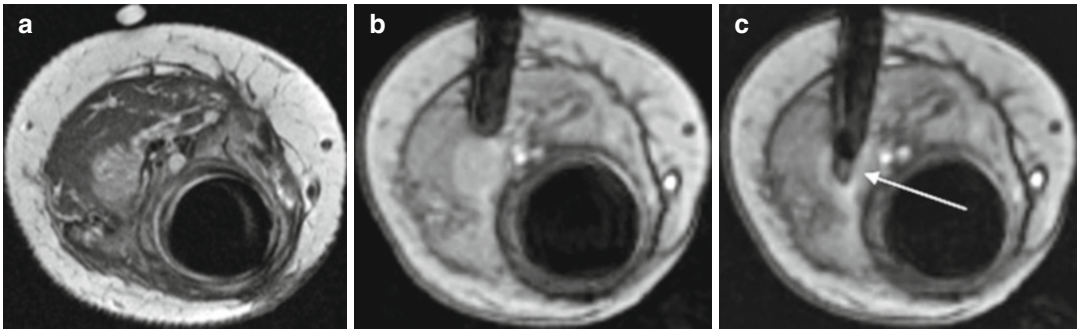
A 14-year-old girl with tumor-prosthesis of the tibia due to osteosarcoma and a new lesion adjacent to the tibia, which was invisible in CT due to metal artefacts. (a) Definition of the skin access site using an Adalat® capsule.
